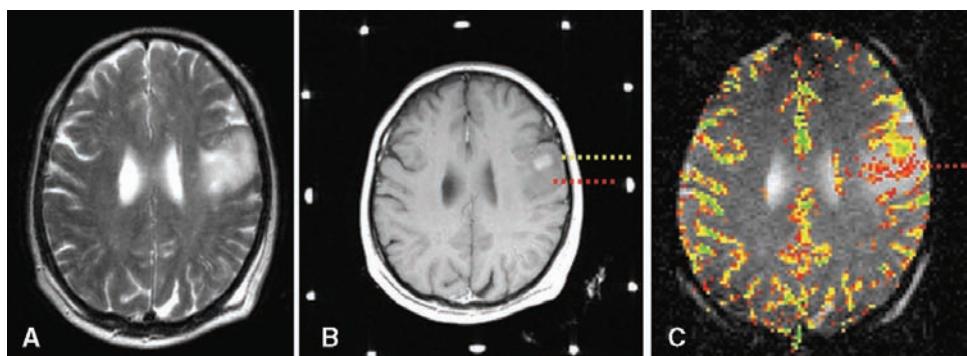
Minimally enhancing left frontal lobe tumor in a 50-year-old man. (A) Axial T2-weighted image shows a hyperintense mass in the left frontal region with minimal surrounding edema. (B) Axial T1-weighted image postgadolinium in a stereotactic headframe shows a small nodule of enhancement anteriorly within the tumor. (C) DSC MRI color overlay imaging as seen by the neurosurgeon in the operating room at the time of surgery, demonstrating increased perfusion posterior to the focus of enhancement. Two separate stereotactic biopsies were performed. The biopsy of the enhancing nodule revealed a low-grade glioma (yellow biopsy), whereas the biopsy of the focus of increased perfusion posteriorly (red biopsy) demonstrated an anaplastic astrocytoma. This was confirmed at subsequent surgical resection of the tumor. Abbreviation: DSC MRI, dynamic susceptibility contrast MRI.
